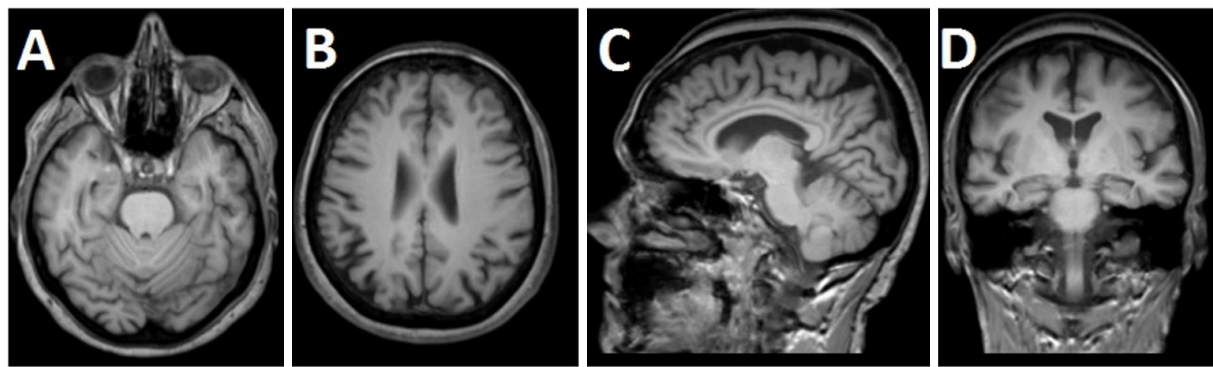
Brain magnetic resonance imaging of case 1 (T1 sequence), showing relative preservation of the hippocampus (A,D) and some degree of parietal atrophy (B,C)
